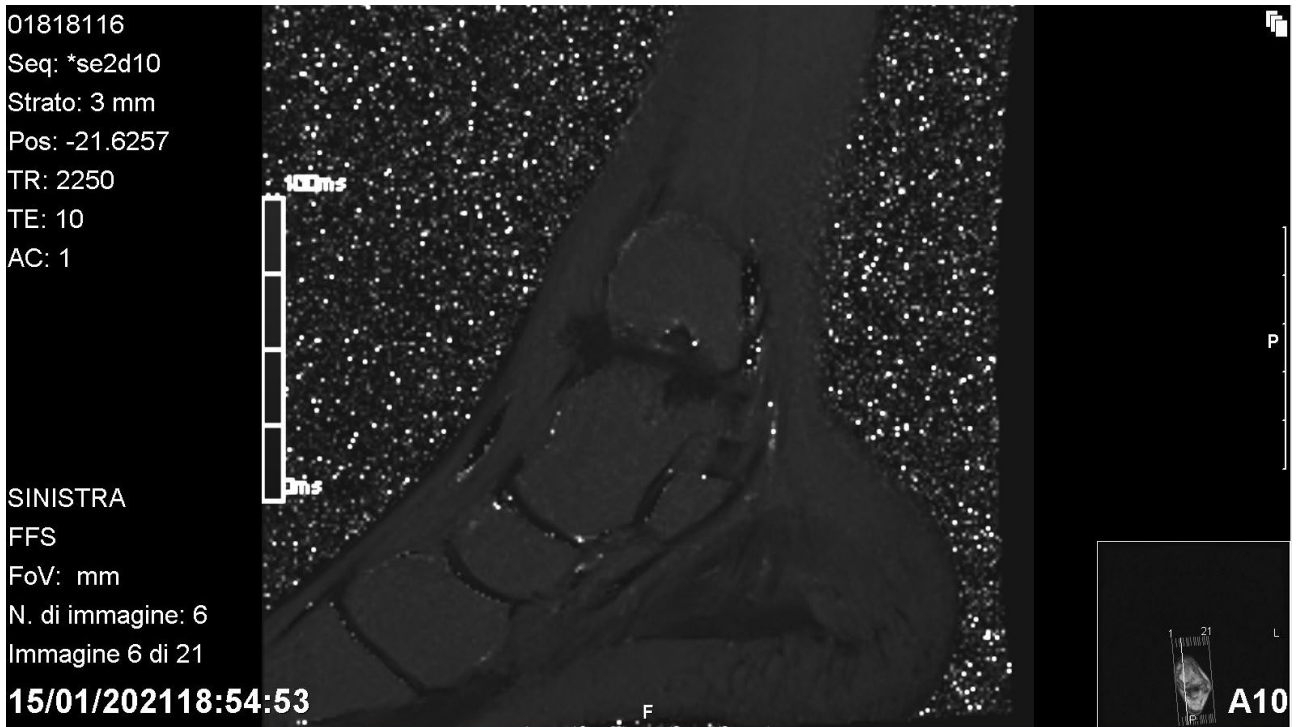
MRI T2-mapping of OLT
